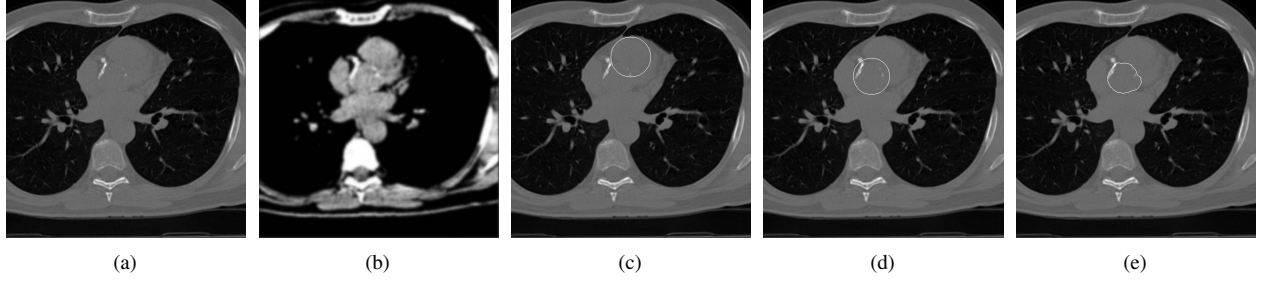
(a) Unprocessed original CT image, (b) pre-processed enhanced image, (c) detected circle as global maximum in Hough space, (d) detected circle using dynamic programming, and (e) boundary contour detected by dynamic programming.
